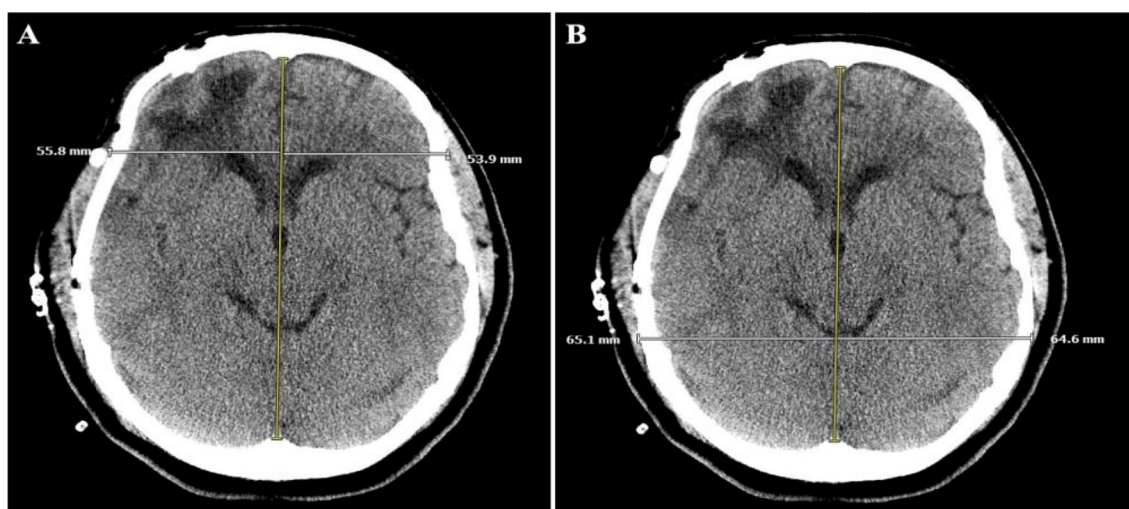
A CT scan image depicting the measurement of frontal asymmetry at the third ventricle level. B Measurement of parietal asymmetry at the point of maximum biparietal diameter
